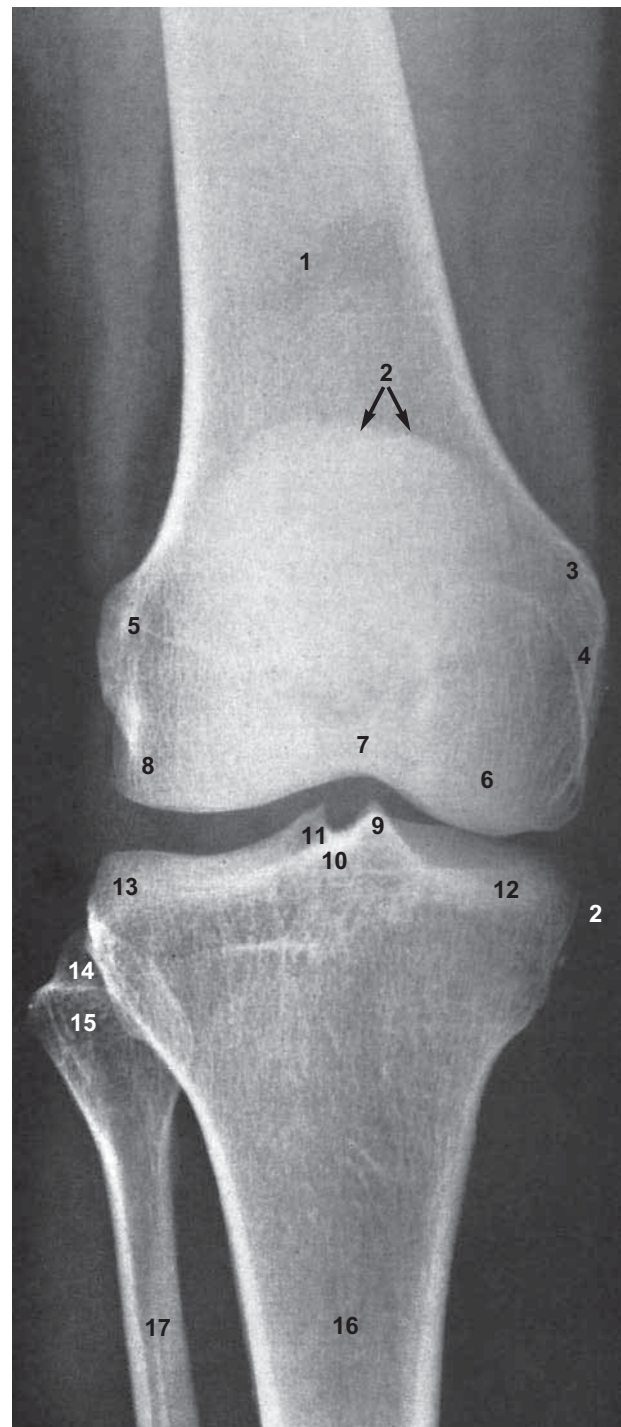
Radiograph of the Right Knee (Anteroposterior Projection)
